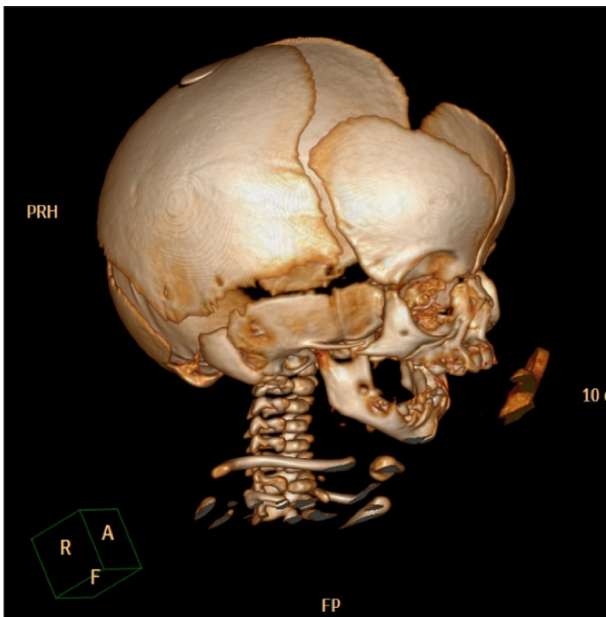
Lateral view of 3D cranio-encephalic CT scan highlighting large anterior fontanelle and mandibular hypoplasia.
